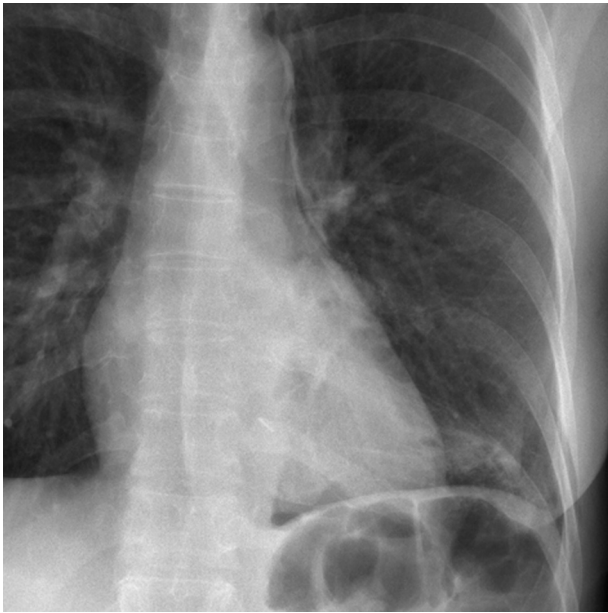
Control chest radiography 3 months after surgery is normal.
